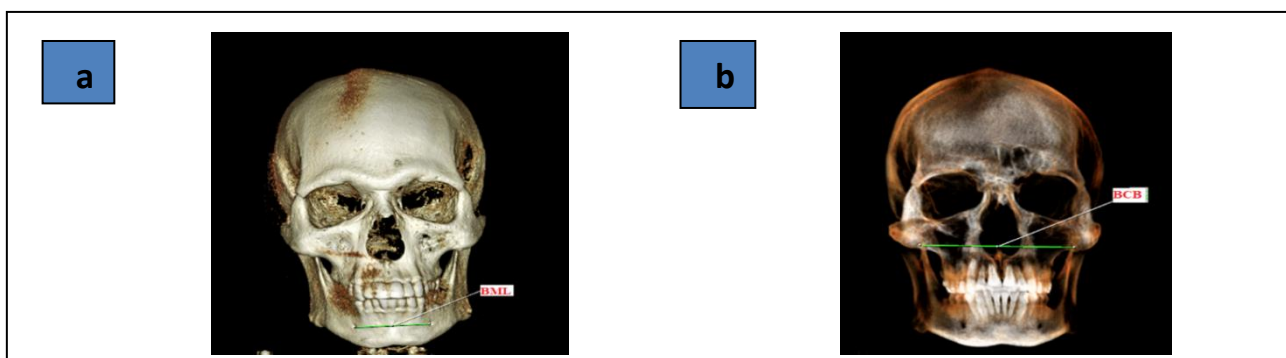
Anterior view of full skull CBCT, a: BML, bi-mental length, b: BCB, bi-coronoid breadth.
